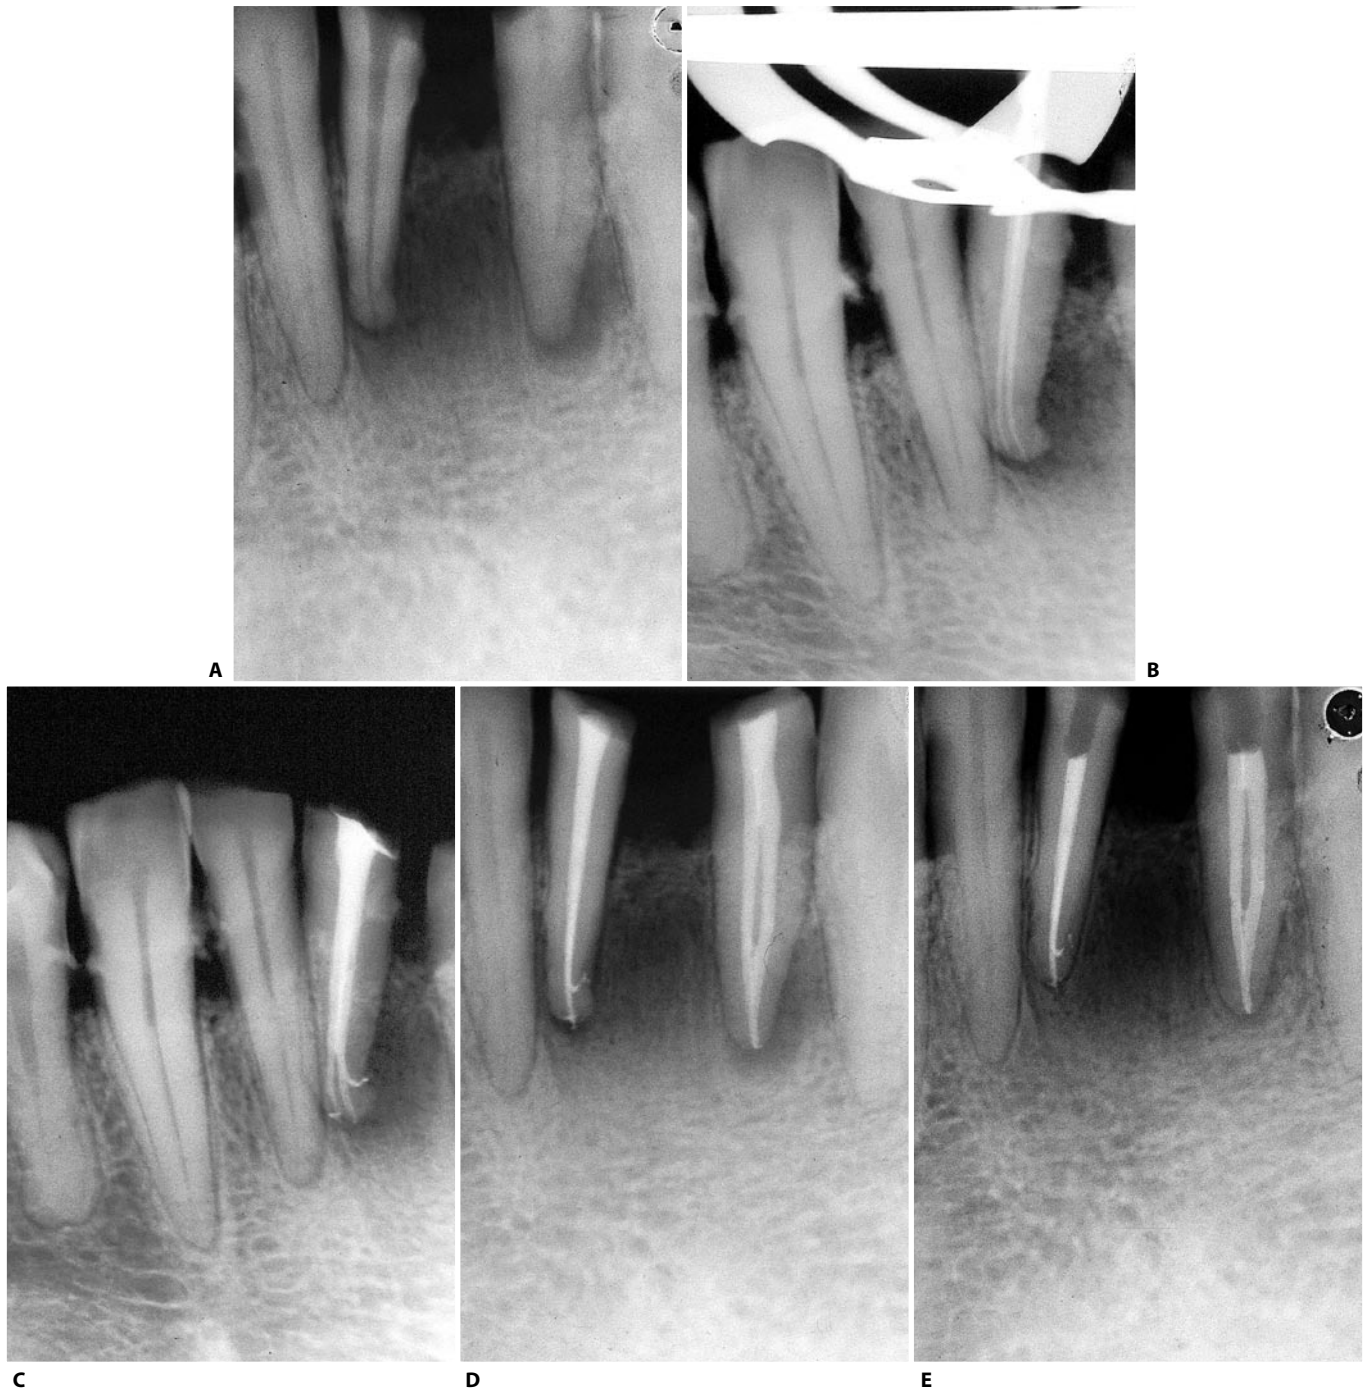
The two anatomical variants of the lower incisor with two canals are present in the same patient. The right central incisor has two canals with independent foramina, while the left lateral incisor has two canals with a common apical foramen. A. Preoperative radiograph. B. Intraoperative radiograph confirms the presence of two independent canals. C. Postoperative radiograph. A lateral canal is also visible. D. Postoperative radiograph of the left lateral incisor: the two canals become confluent. E. Two year recall (Courtesy of Dr. R. Becciani).
